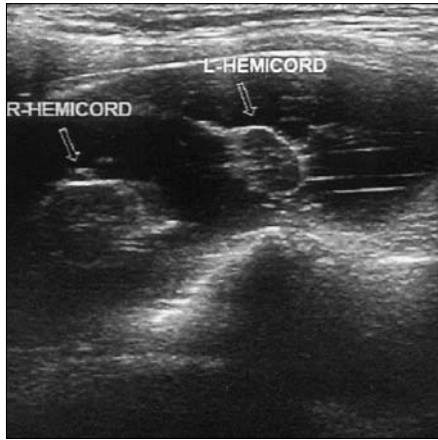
Transverse ultrasonographic image reveals the right and left hemicord in central position, with nerve roots extending along both hemicords. Thin septal structures within the dural sac are also noted.
